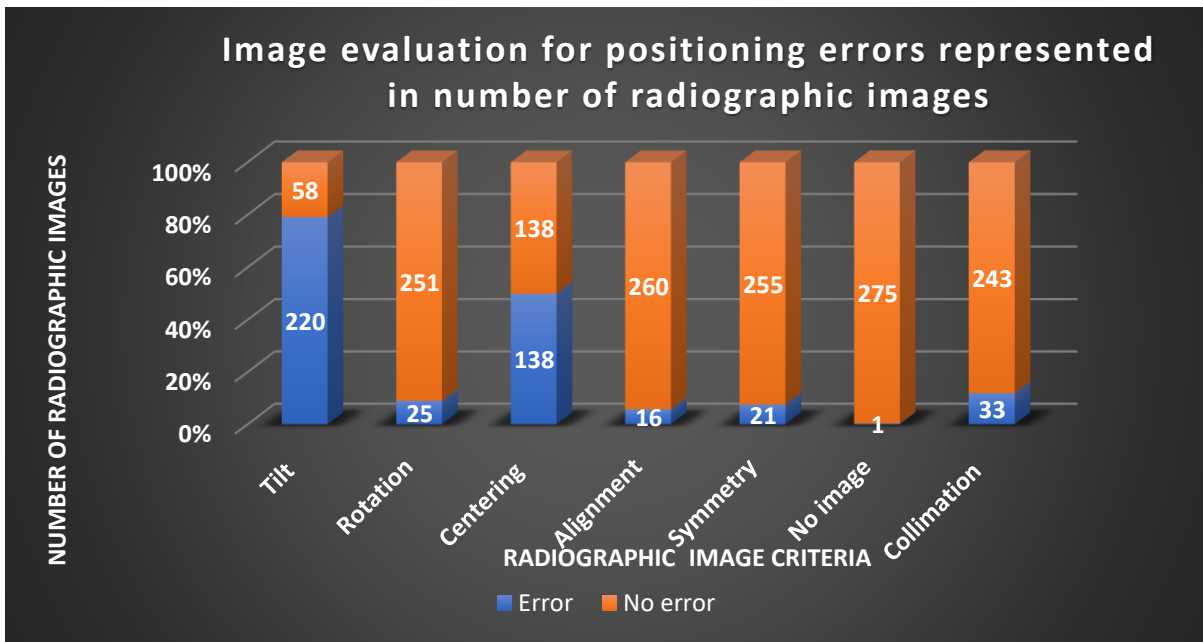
Radiographic image evaluation for positioning (created by the researcher)
